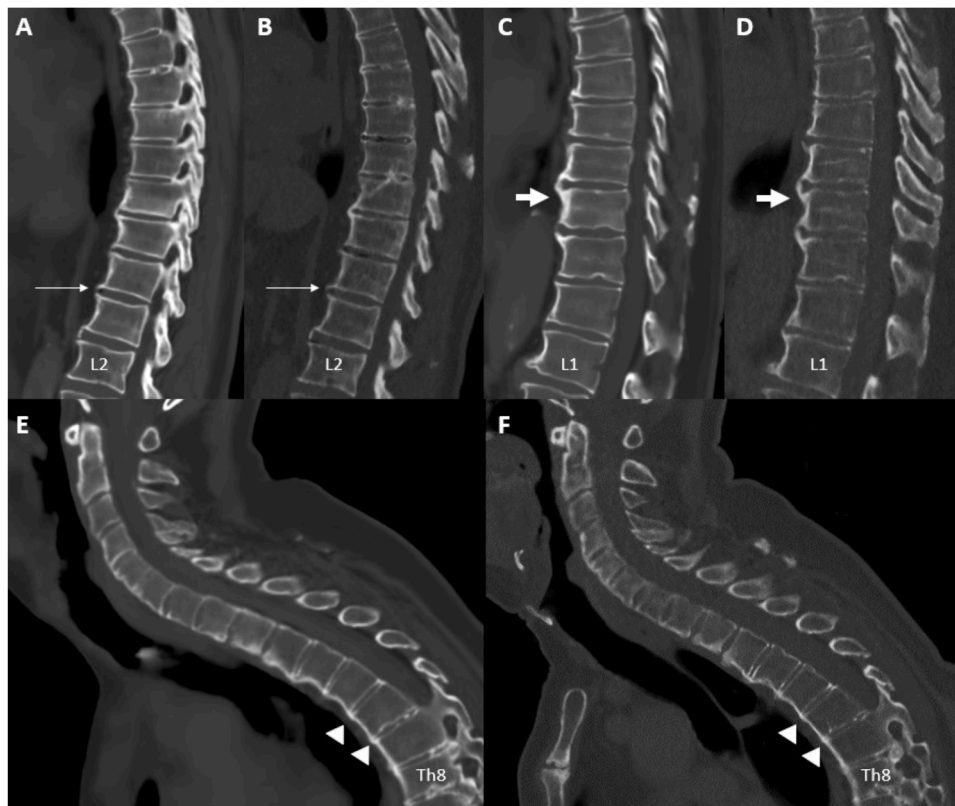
MRI-based synthetic computed tomography (A, C, E) and low-dose computed tomography (B, D, F) of the thoracolumbar spine (A+B, C+D) and cervical and part of the thoracic spine (E+F) in three patients with axial spondyloarthritis.
